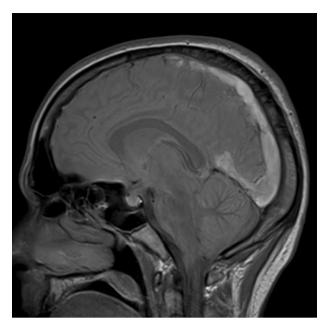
MRI of the brain showing signal hyperintensity of the superior longitudinal sinus, the straight sinus, and the proximal portion of the transverse sinuses.
